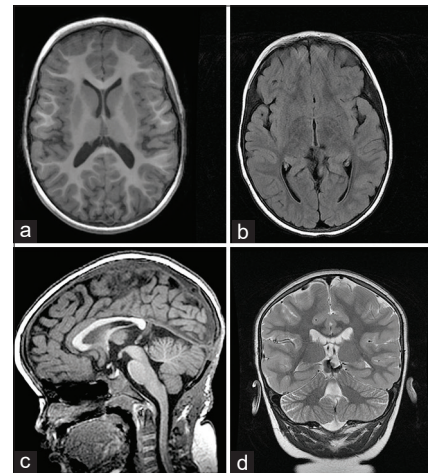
(a) Axial T1 2 months after endoscopic ventriculostomy and total excision of the lesion of the pineal region, (b) axial FLAIR showing nondilated temporal horns, (c) T1 sagittal showing repermeability of Sylvius aqueduct, and (d) T2 coronal showing a small blood residue, no mass effect and without hydrocephalus signals.
